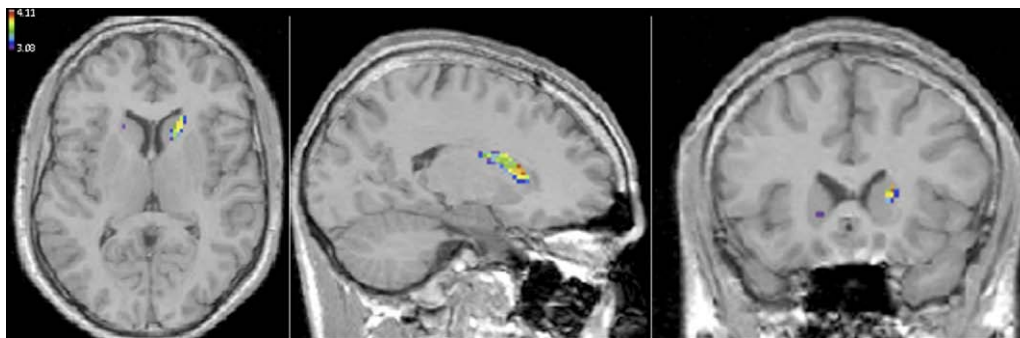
Focal increases in gray matter density in autism. The map is thresholded at the critical t ($t > 3.08$) and superimposed on axial, sagittal, and coronal sections through the magnetic resonance image of the model brain.
